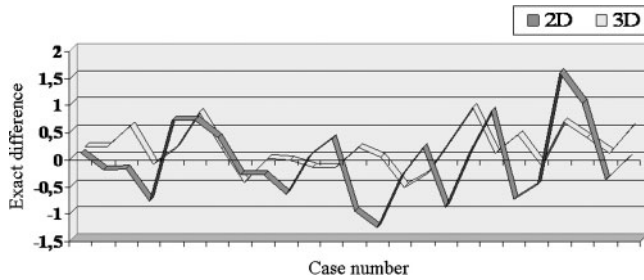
Line chart derived from the measurement data. The lines represent the exact difference from the gold standard of the bone level measurements on both three-dimensional (3D) cross-sectional cone beam CT slices and two-dimensional (2D) charge-coupled device, allowing visualization of over- and underestimations and measurement deviations
